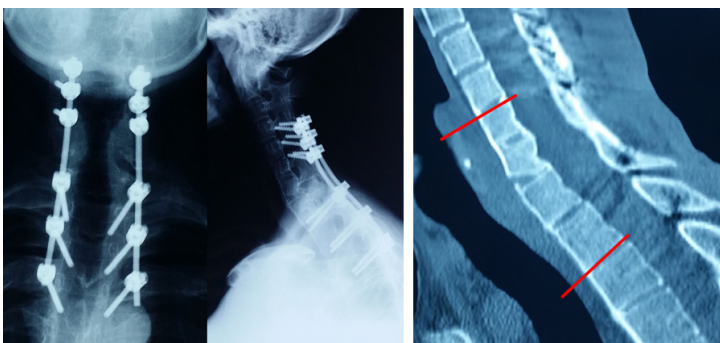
The X-ray and CT scan on six-month follow up demonstrate that solid bone fusion between posterior part of lower C6 endplate and upper C7 endplate has been achieved, bone fusion of intra-laminae between C5 and C7 has also been demonstrated.
